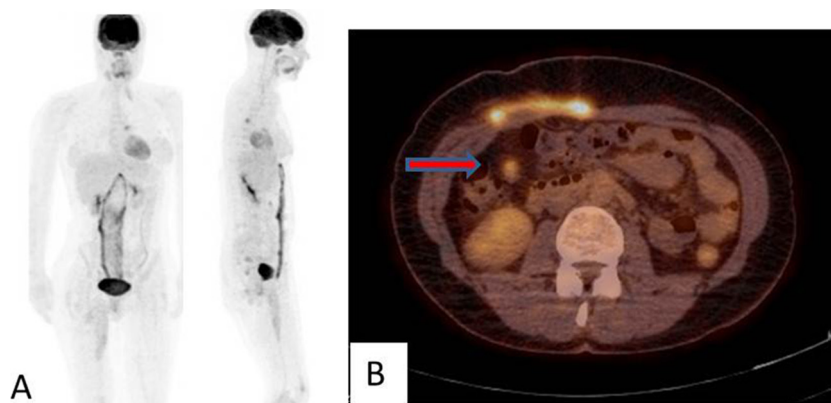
A) Coronal FDG PET image showing the periprosthetic seroma uptake multiple omental nodes and an hilar mediastinal hypermetabolic foci. B) Axial section of the hybrid fused FDG PET-CT. The red arrow is pointing to a small round lesion in the right upper quadrant, most likely representing omental lesions.
